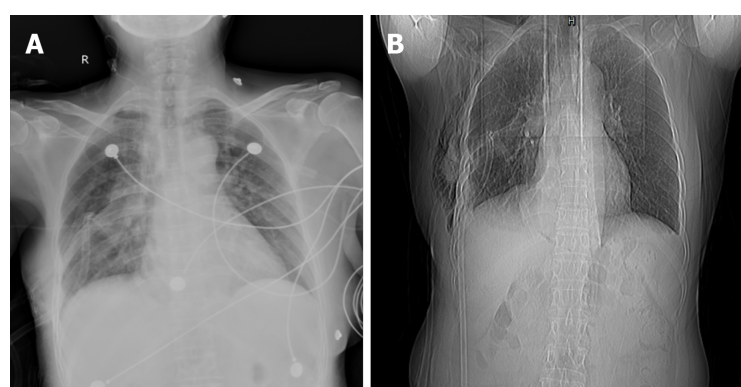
Postoperative examination. A: Immediate postoperative chest X-ray showed ill-defined frosted hyaline shadow with exudative lesions in both lungs; B: At postoperative day 6, follow-up chest X-ray showed exudative lesions in both lungs were markedly reduced.
